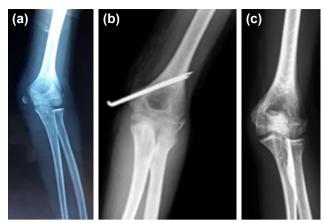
An 8-year-old boy suffered from a fracture of the right medial humeral epicondyle because of a simple fall. (a) The initial radiograph demonstrates the displaced fragment pulled by the ulnar collateral ligament. (b) The fragment was fixed with K-wires from the medial side in an anatomic position. (c) The final follow-up radiograph shows a solid union.
